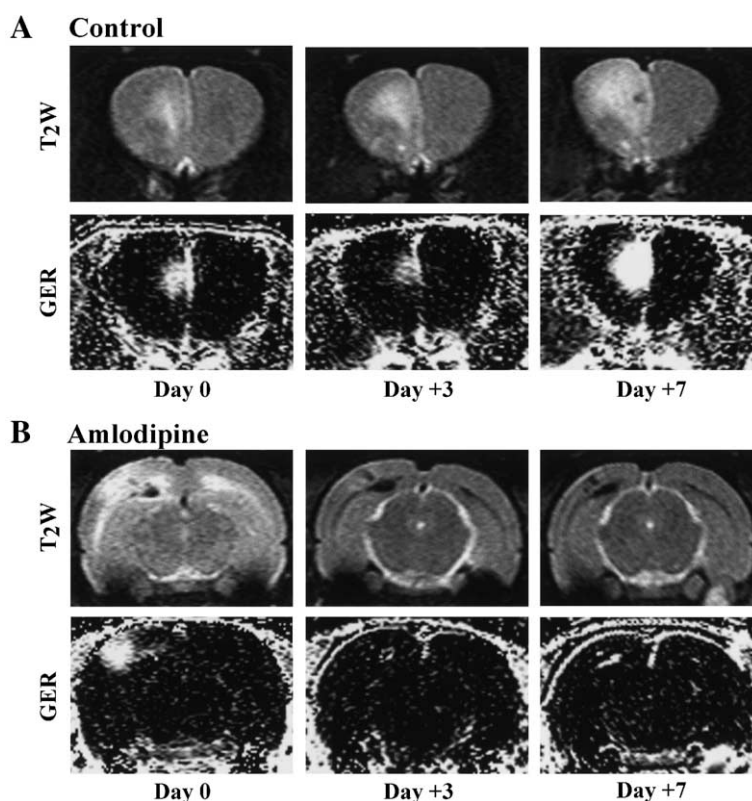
(A) Upper row: typical MR images of progression of cerebral injury in control SHRSP in the first week after detection of cerebral edema (day 0). T₂WMRI shows an expanding area affected with cerebral edema with a hemorrhagic focus (i.e. hypointensity) appearing on day 7. Lower row: typical GER images (calculated from pre and post contrast Gadopentetate dimeglumine enhanced images) of progression of leakage through the blood–brain barrier in control SHRSP in the first week after detection of leakage (day 0). (B) Upper row: typical MR images of reduction of cerebral injury in amlodipine-treated SHRSP in the first week after detection of cerebral edema (day 0). T₂WMRI shows that cerebral edema had disappeared within 3 days. An area affected by hemorrhage on day 0 remains visible. Lower row: typical GER images of regression of leakage through the blood–brain barrier in amlodipine-treated SHRSP within 3 days after detection of leakage (day 0).
